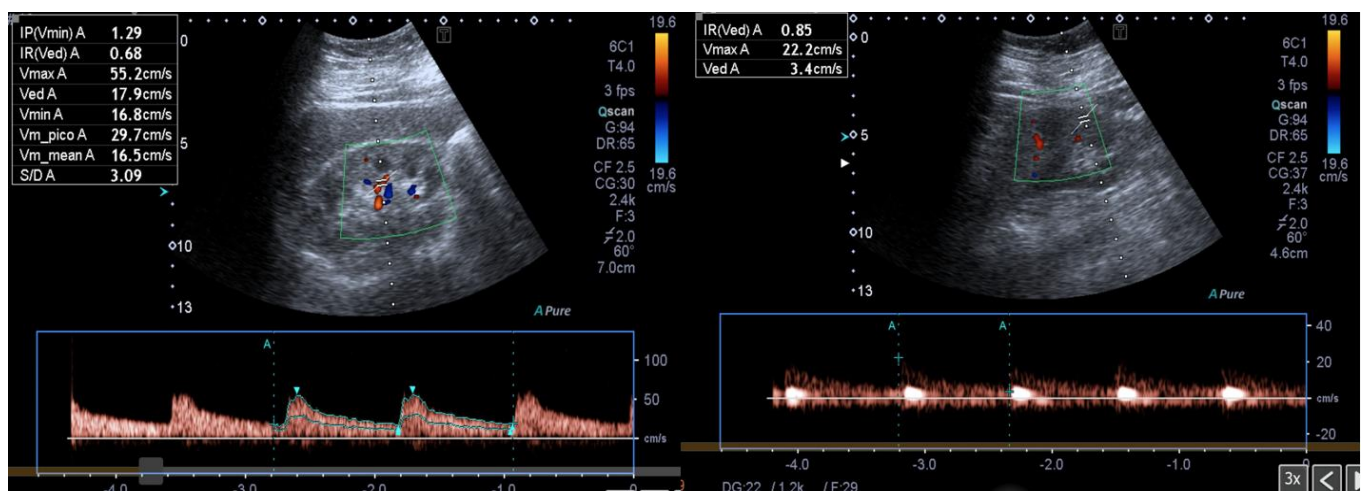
Renal Doppler ultrasonography, both kidneys are observed with preserved morphology and echogenicity, without evidence of lesions. On color Doppler test, no evidence of alterations in both renal arteries and veins, of adequate caliber. Doppler study with preserved flow morphology, color flow and normal spectra.
